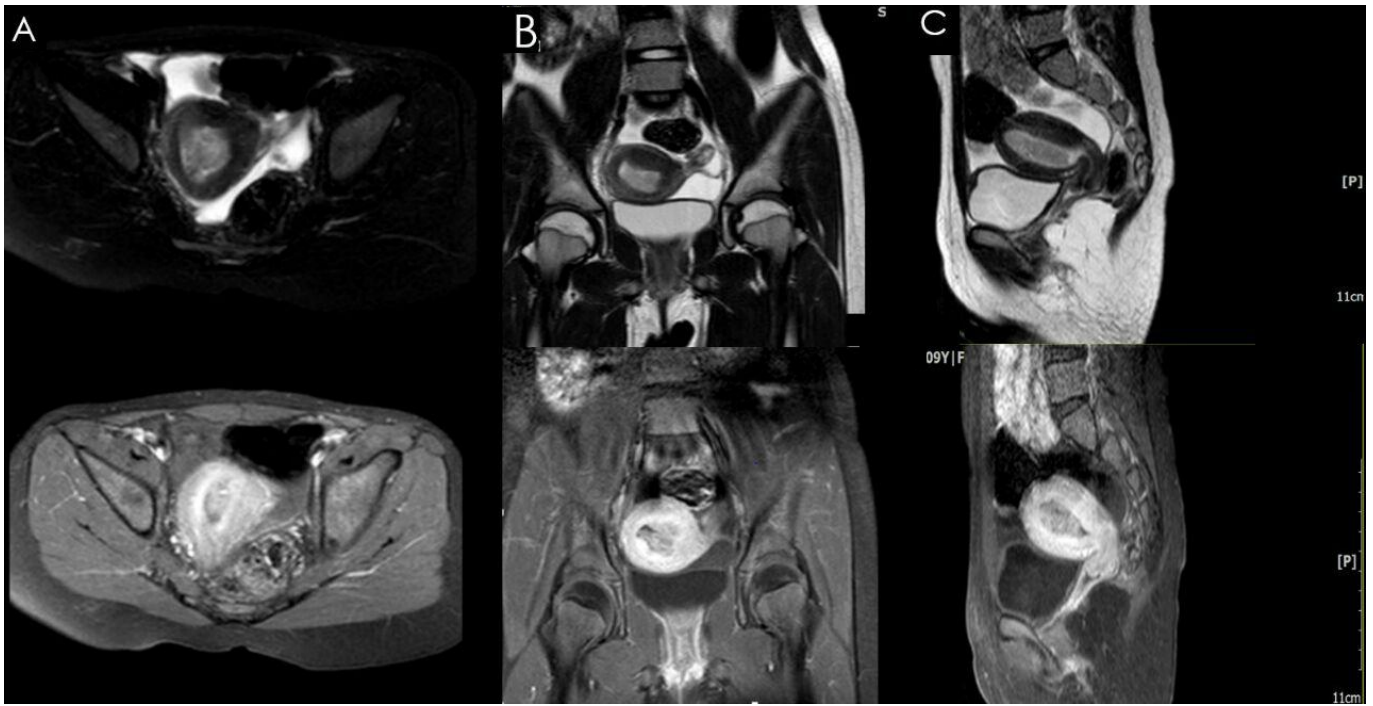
MRI shows a normal endometrium and myometrium with a mass originating in the corpus body (sagittal, coronal, axial view in T1 & T2 gradient slice; A, B, C).
